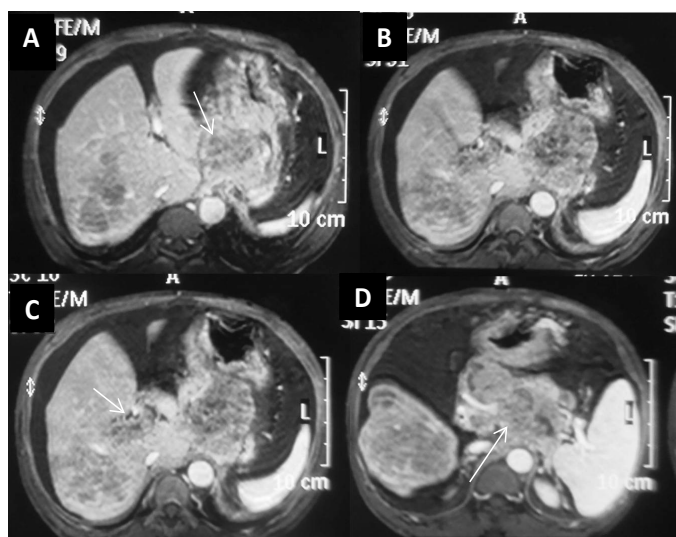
(A-D) Axial post gadolinium MR images showing large heterogeneously enhancing mass lesion arising from lesser curvature of stomach (A) extending into gastrohepatic region (arrow), with large mass lesion in right lobe of liver (B) with contiguous extension of tumor thrombus in to main portal vein (C) (arrow), with involvement of the celiac axis by the stomach mass (D) (arrow).
